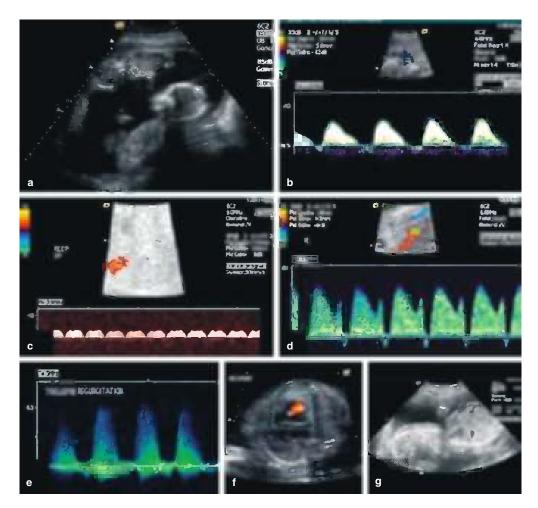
Ultrasound and Doppler findings in twin–twin transfusion syndrome (TTTS). Features of stage II TTTS include oligohydramnios–polyhydramnios sequence with growth discordance and non-visualization of donor bladder (a). Manifestations of hemodynamic compromise in stage III TTTS include reversed end-diastolic frequencies (REDF) in umbilical artery of donor twin (b), and pulsatile flow in umbilical vein (c), reversed flow in ductus venosus (d) and marked tricuspid regurgitation (e,f) in recipient. Worsening cardiovascular dynamics in recipient result in fetal hydrops, i.e. stage IV (g)
